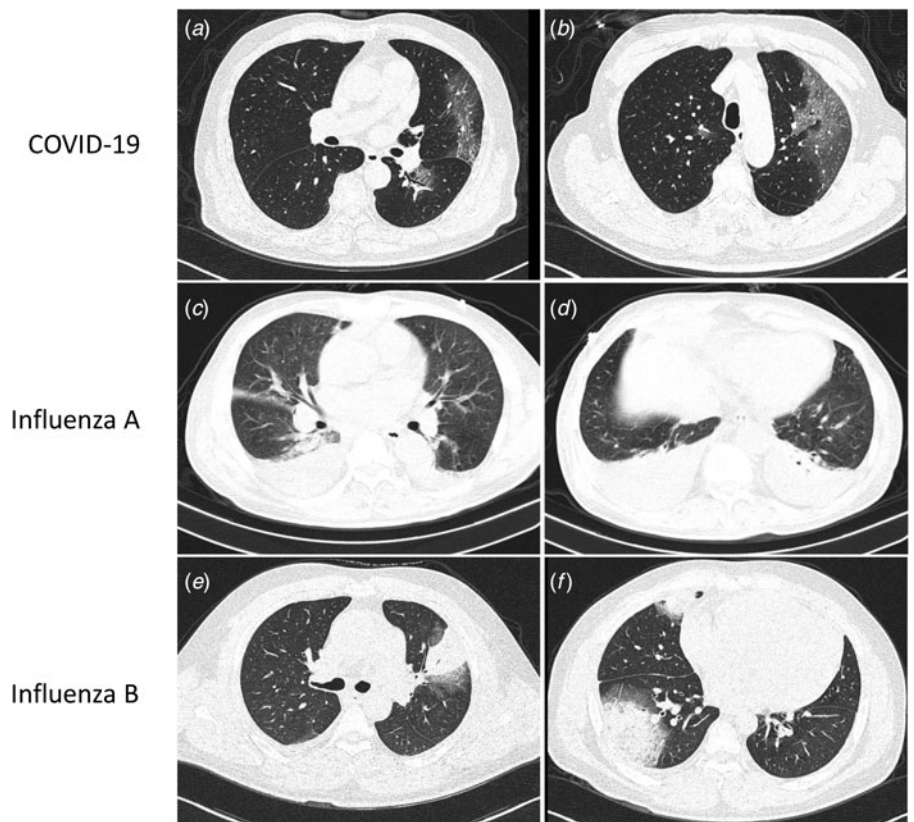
Different CT findings of COVID-19, influenza A viruses, influenza B virus-related pneumonia in our institution. (a, b) Patients with COVID-19 presented GGOs with enlarged vascular in the lesions. (c, d) Patients with influenza A presented bilateral pleural effusion. (e, f): Patients with influenza B presented bilateral consolidations predominant lesions.
